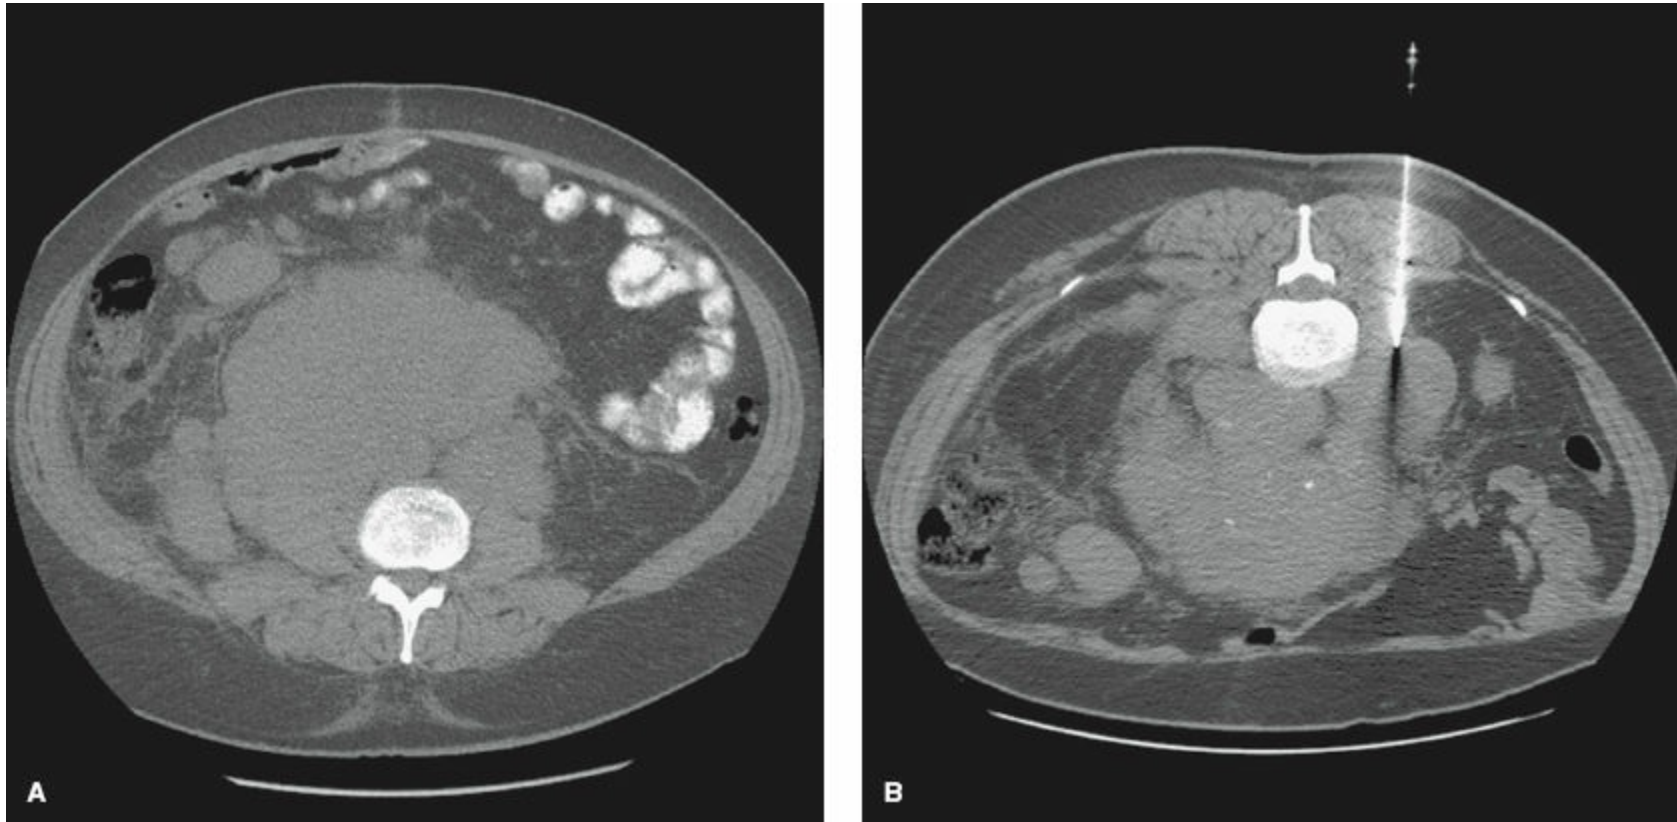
Biopsy can be helpful in the workup of retroperitoneal masses. A: CT scan shows a retroperitoneal mass encasing the IVC and aorta. B: Image-guided biopsy is demonstrated here. Pathology confirmed a diagnosis of large B-cell lymphoma.
